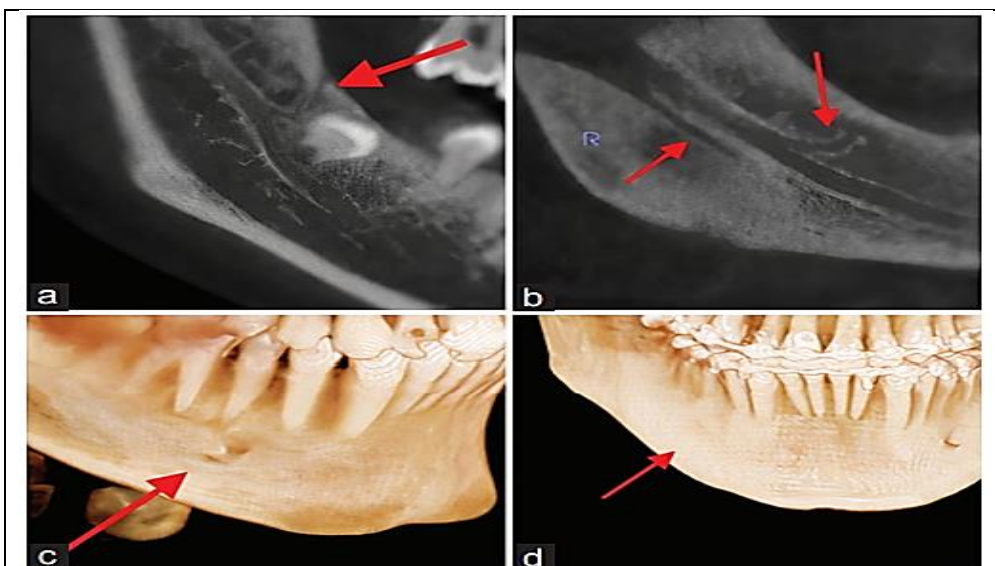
Variations in cone-beam computed tomography Images; (a) bifid mandibular canal, (b) trifid mandibular canal, (c) accessory mental foramen, (d) no mental foramen
